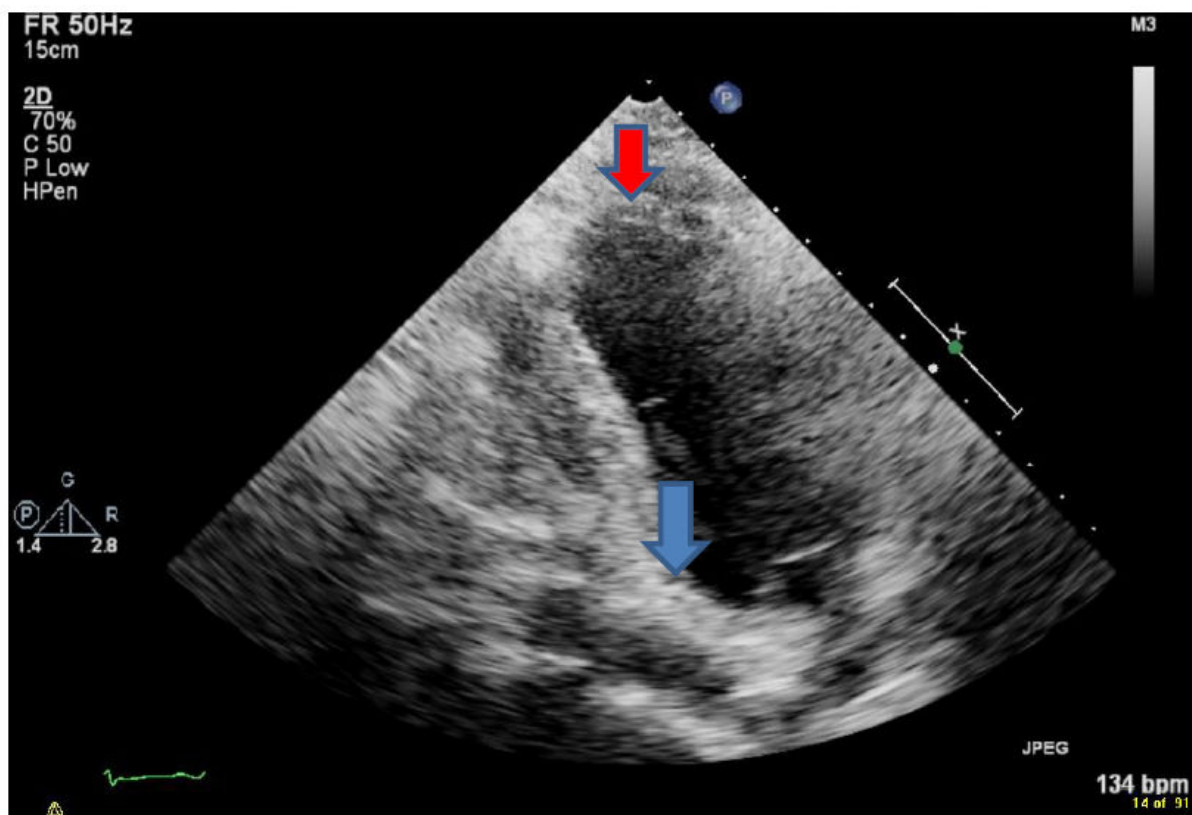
Transthoracic Echocardiography two chamber view showed diastolic phase of left ventricle, and inferior basal wall did not show any movement. Only apical wall moved up compared to Figure 1, (See red arrow), however, inferior basal wall did not move well. It suggests hypokinesis of inferior basal wall in left ventricle.
